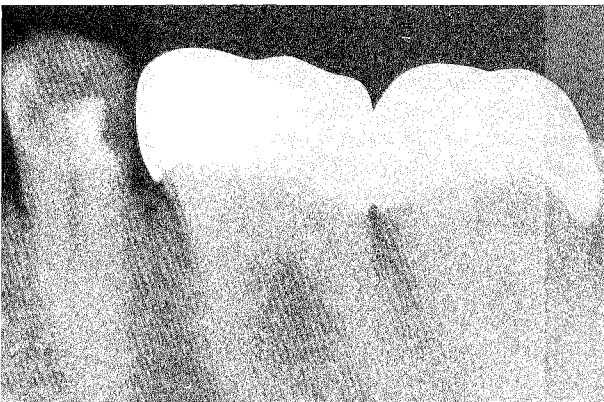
An x-ray reveals pulp and periodontal anatomy to aid in planning pin placement.*
